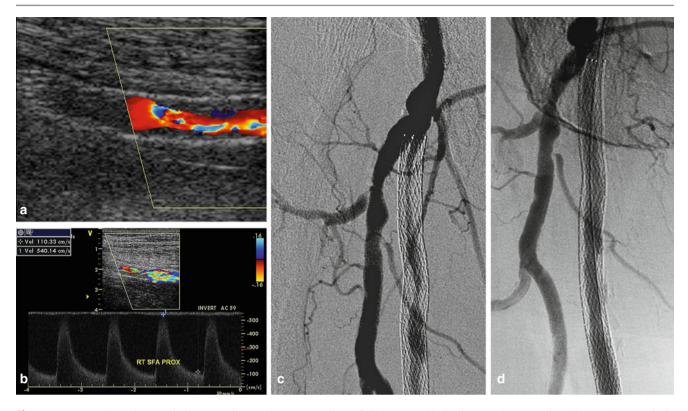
(a) Duplex ultrasound demonstrating moderate stenosis with an elevated peak systolic velocity of 200 cm/s in midportion of SFA stent. (b) Duplex ultrasound demonstrating high-grade stenosis with an elevated peak systolic velocity of 540 cm/s in proximal portion
